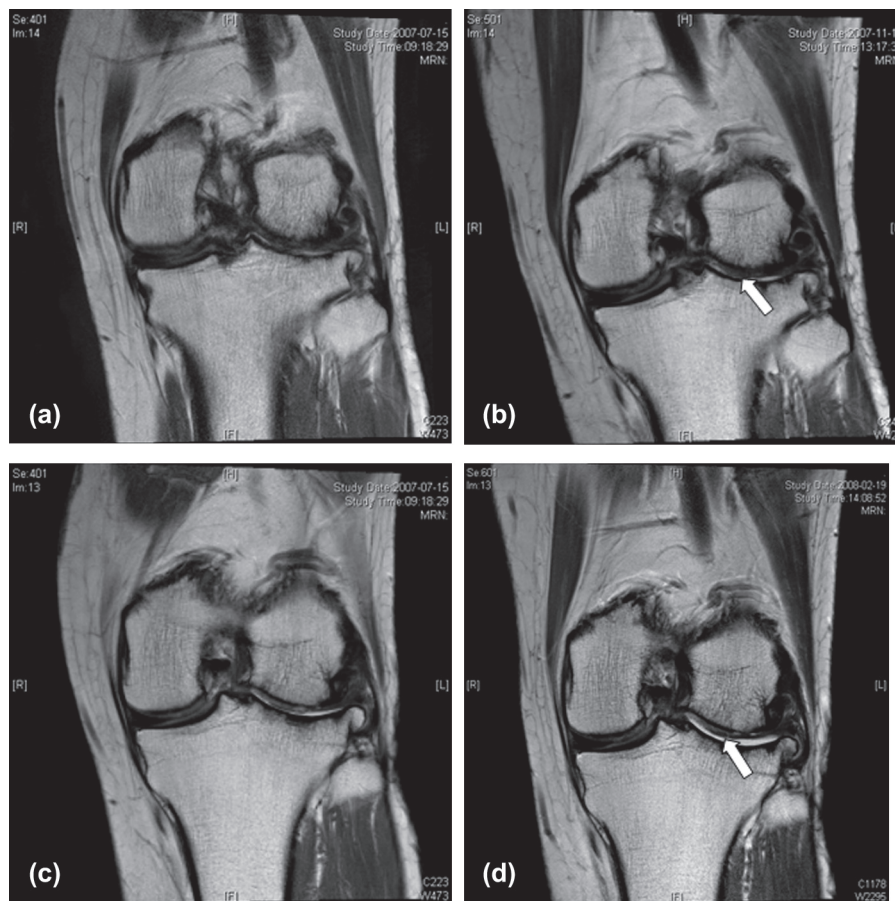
Proton-density coronal magnetic resonance image for patient 007 at baseline (a, c), 3 months (b) and 6 months (d). The appearance of subtle cartilage regeneration is seen in (b) and (d) at the weight-bearing portion of the lateral femoral condyle, as indicated with the arrow.
